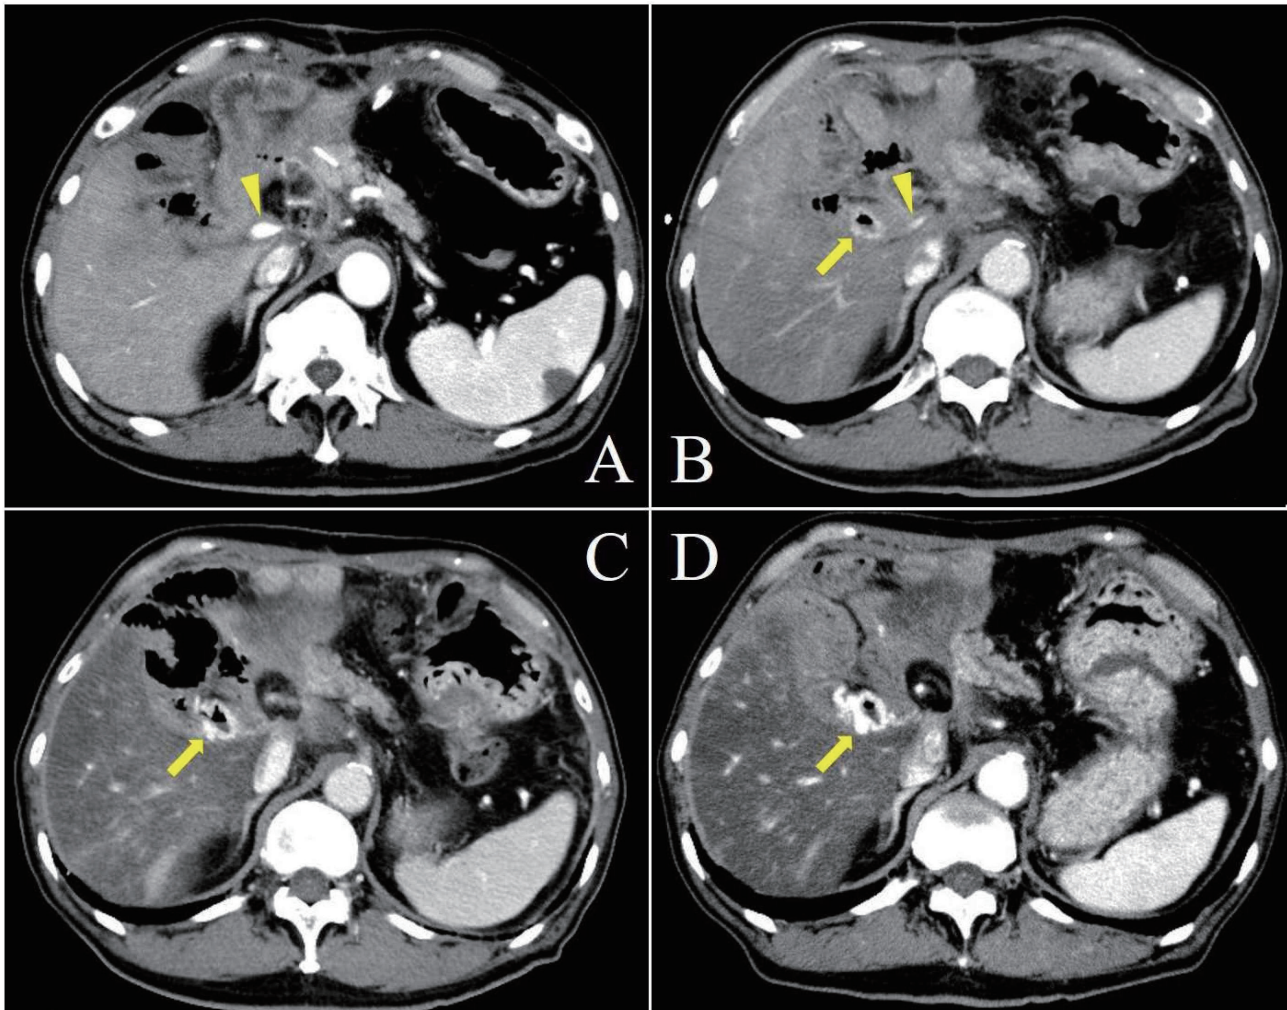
Follow-up computed tomography (CT) imaging after emergency interventional radiology. (A) The first follow-up CT indicates that the reconstructed portal vein is narrowed by a structure consisting of granulation tissue around the portal vein (arrowhead). (B) CT at readmission demonstrates severe stenosis of the portal vein (arrowhead) and small collateral vessels around the hepaticojejunostomy site (arrow). (C) Varices around the hepaticojejunostomy site (arrow) and fatty liver had gradually have developed for 6 months after surgery. (D) CT at the second readmission shows both progression of the fatty liver caused by the decreased portal flow as well as the development of varices around the hepaticojejunostomy site.
